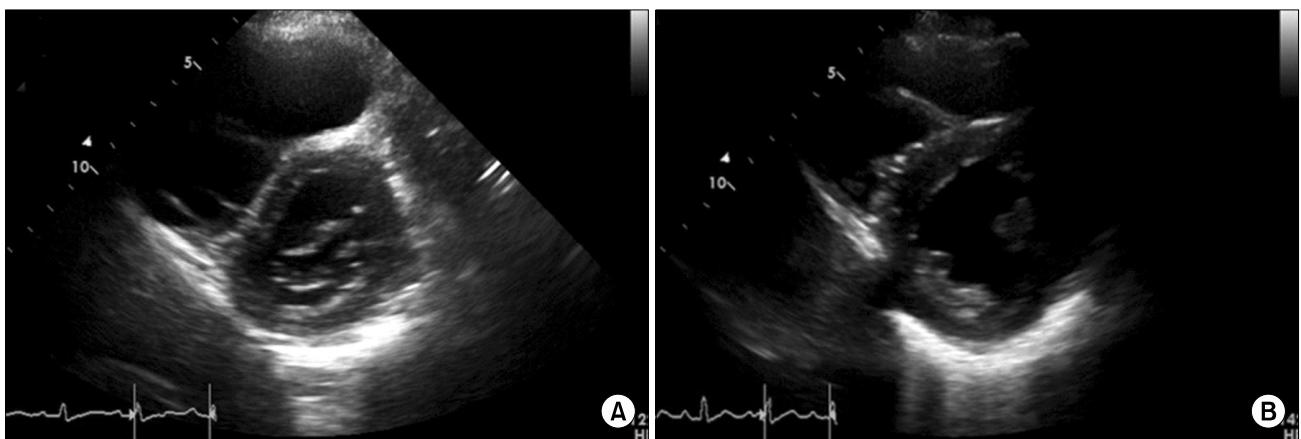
(A) On transthoracic echocardiography, an enlarged right ventricle and flattened inverted septum were found with diminished right ventricular function. (B) After changing the mode of extracorporeal membrane oxygenation, decreased right ventricular size and improved right ventricular function were noted.
